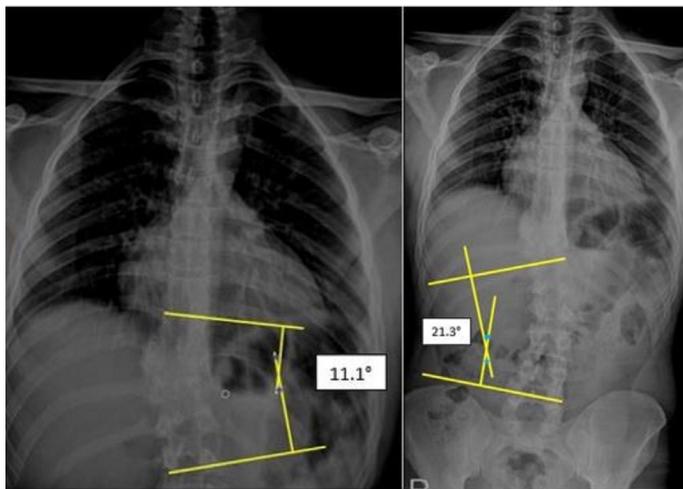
The measurement of Cobb angle on the chest x-ray and spine orthoroentgenogram graphy is shown. Although the main curvature was seen in the thoracic vertebra in the chest X-ray, it was found that the main curvature in the orthoroentgenogram was in the lumbar spine. Therefore, Cobb angle and scoliosis type have changed. Lines were drawn on the film connecting the upper spine at the top of the concave part of the curvature with the lower spine at the bottom of the curvature, and then a perpendicular line was drawn from each line, and the angle where the perpendicular lines intersected was the Cobb angle.
